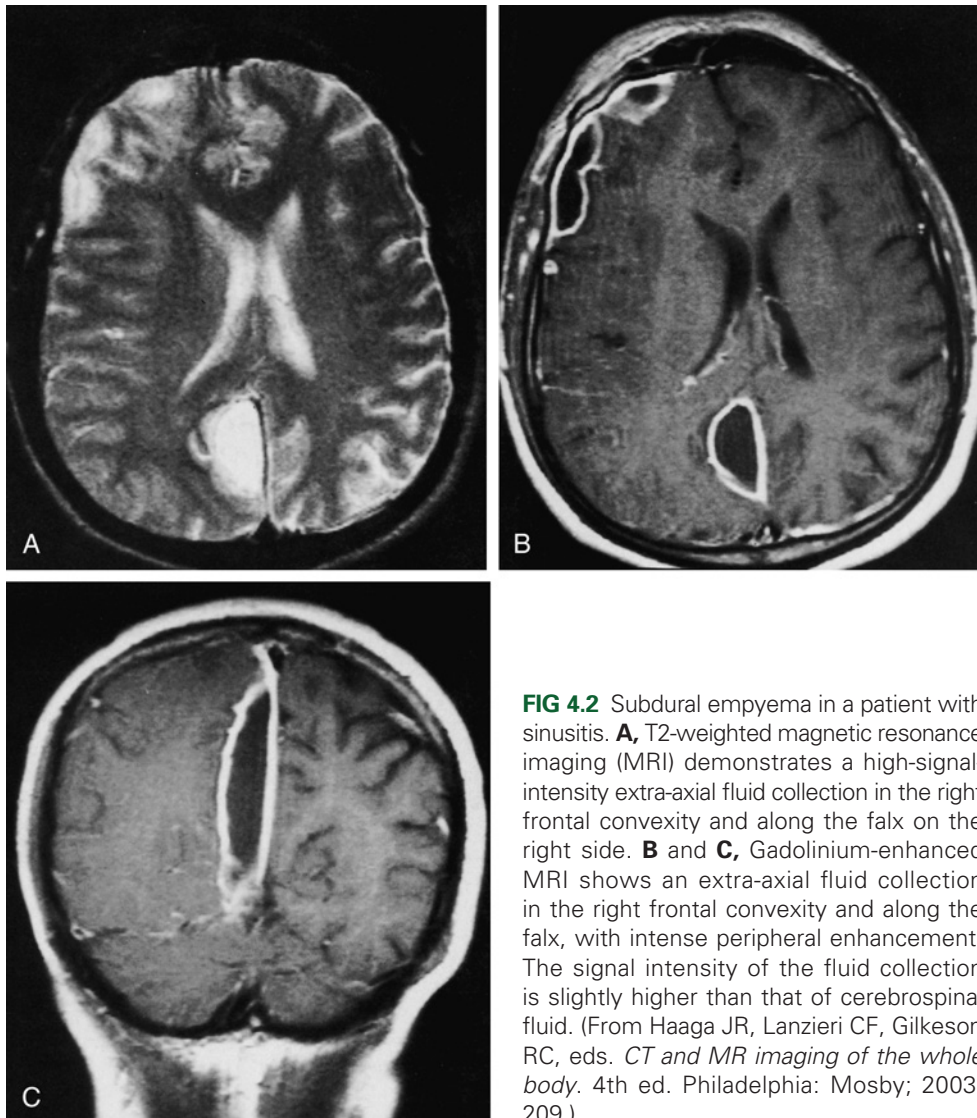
Subdural empyema in a patient with sinusitis. A, T2-weighted magnetic resonance imaging (MRI) demonstrates a high-signal-intensity extra-axial fluid collection in the right frontal convexity and along the falx on the right side. B and C, Gadolinium-enhanced MRI shows an extra-axial fluid collection in the right frontal convexity and along the falx, with intense peripheral enhancement. The signal intensity of the fluid collection is slightly higher than that of cerebrospinal fluid. (From Haaga JR, Lanzieri CF, Gilkeson RC, eds. *CT and MR imaging of the whole body*. 4th ed. Philadelphia: Mosby; 2003: 209.)
